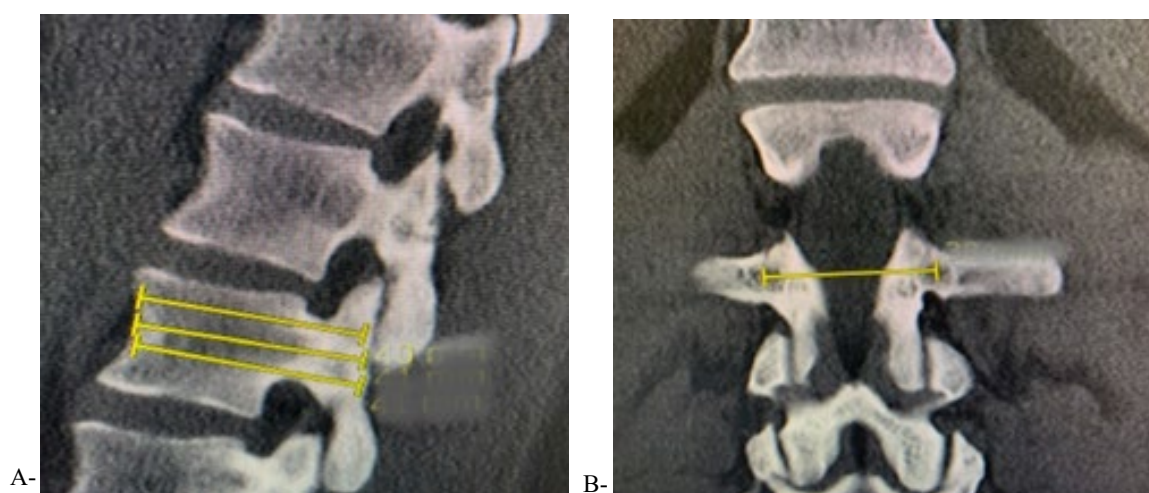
A-B coronal and sagittal CT lumbar spine cuts: A- shows three lines inside the pedicle. The middle line is the correct one which should be registered to the navigation system workstation. B. shows the two correct points on each side inside the cancellous bone.
